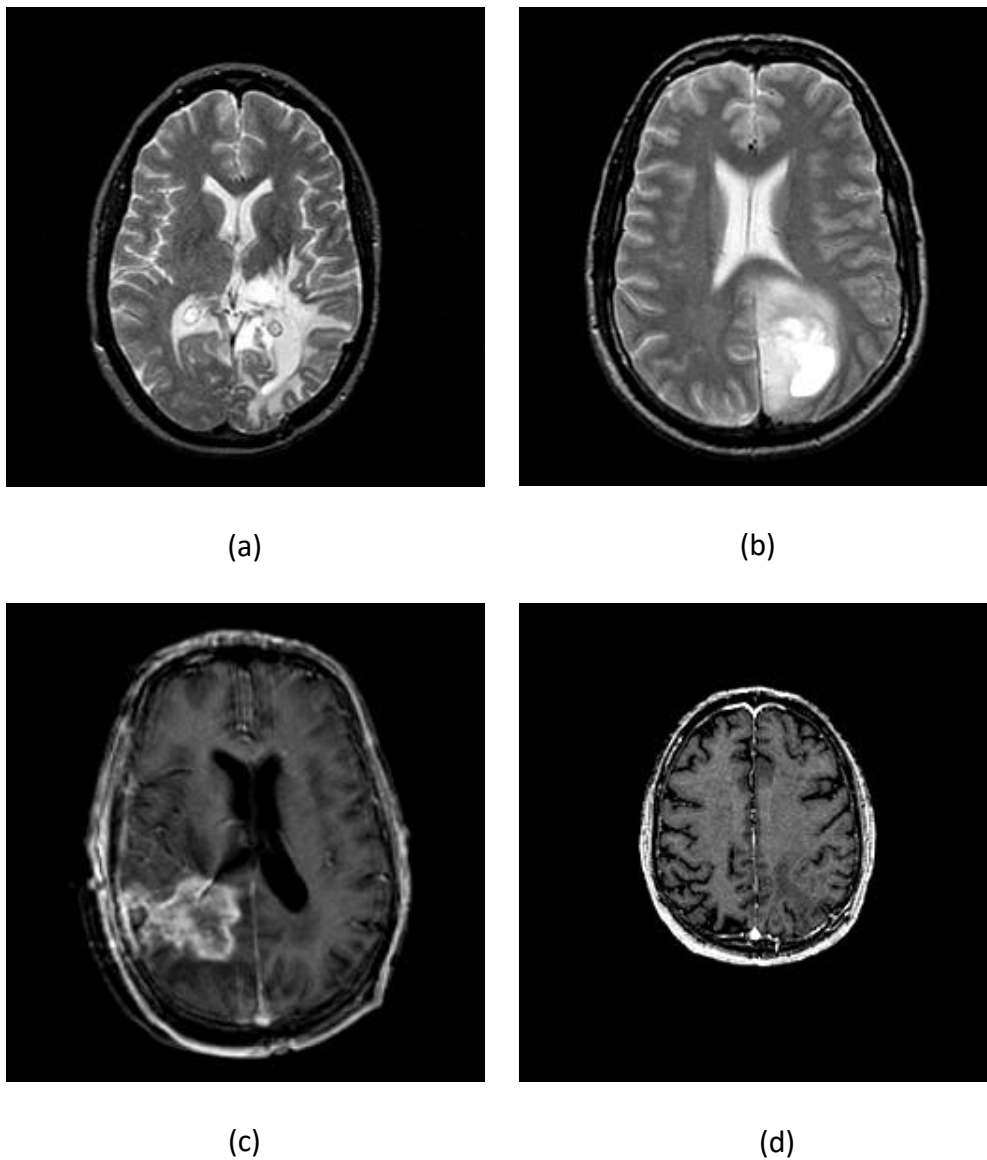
Sample of brain MRI Images: (a-c) abnormal brain; (d) normal brain [100]
